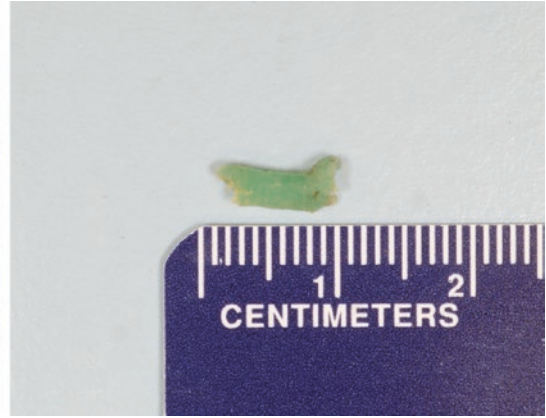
B-scan ultrasonography (left) of 43-year-old gentleman who presented with fusarium endophthalmitis and intraocular foreign body after ruptured globe repair.
